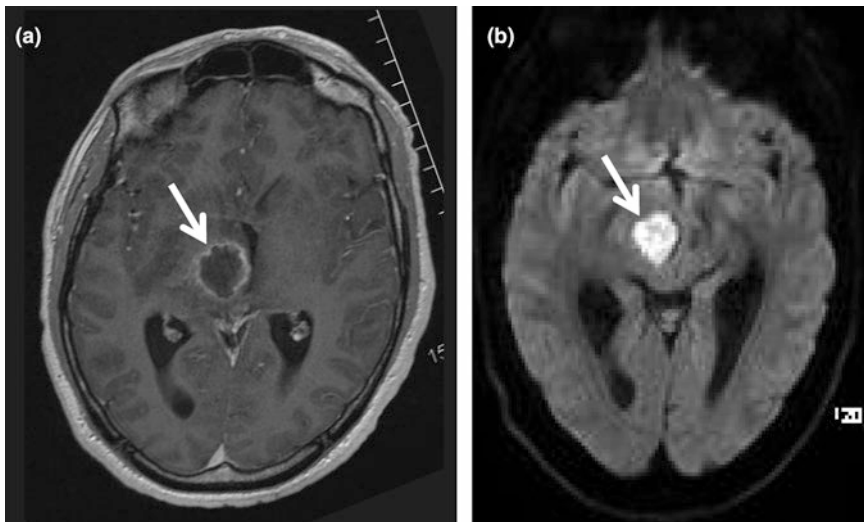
MRI scan performed for an intravenous drug user who presented with headache and sepsis. a This is an image of a T1w post iv contrast (gadolinium) sequence. There is a rim enhancing lesion in the right thalamus (arrow). b This is a diffusion weighted sequence from the same study. The lesion demonstrates central high signal indicative of diffusion restriction. These appearances are consistent with a intracranial abscess
